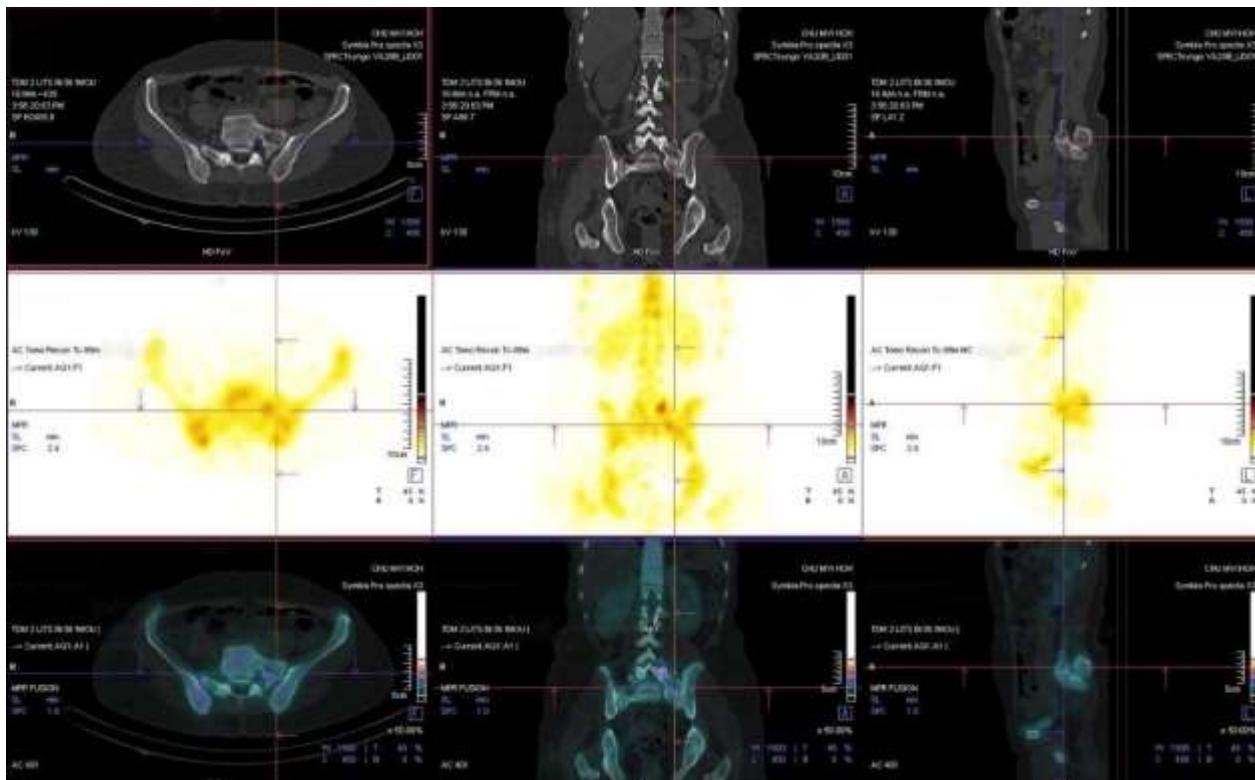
SPECT/CT acquisition of the lumbar spine and sacrum
